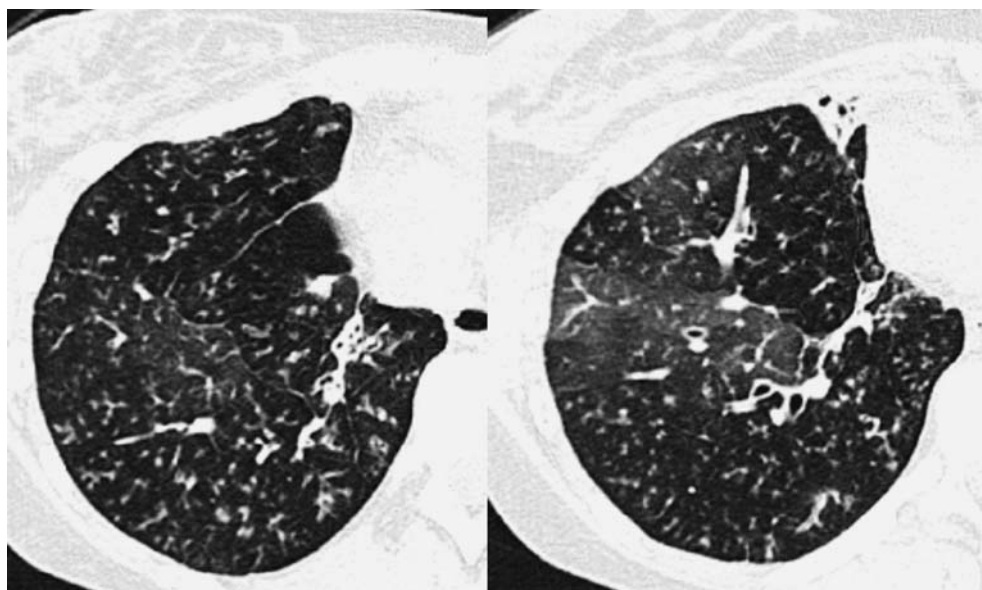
Transverse CT section through the right lower lobe in a lung transplantation recipient in inspiration (*left*) and expiration (*right*). Inspiration section shows peripheral tree-in-bud and subtle inhomogeneity of the lung density. Inhomogeneities are accentuated in expiration and extended air trapping becomes apparent
